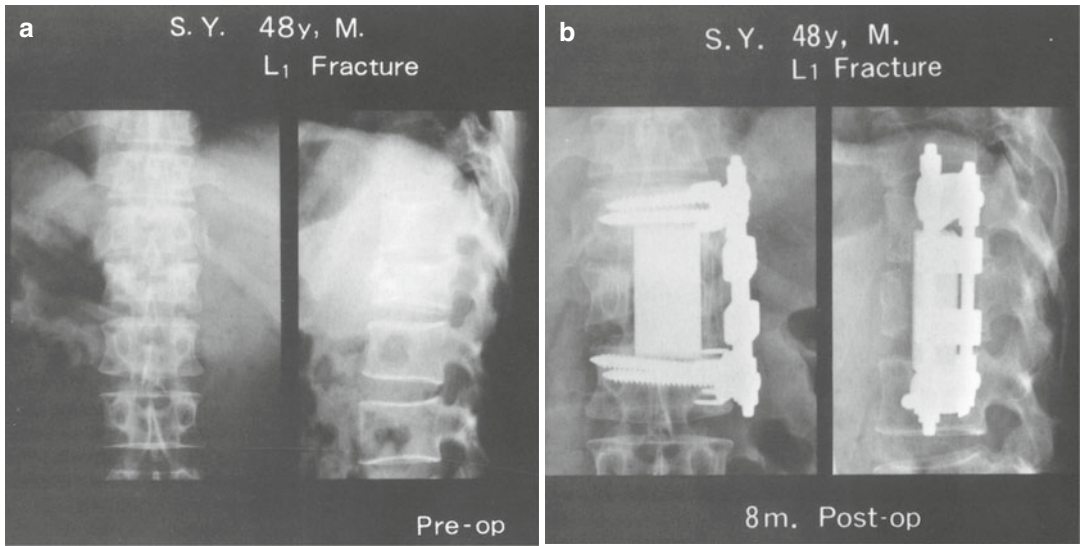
(a) A x-ray picture demonstrating L₁ burst fracture associated with paraplegia developed in a 48 year old male. (b): A postoperative X-ray picture showing a vertebral prosthesis used for the reconstruction of the lumbar spine
